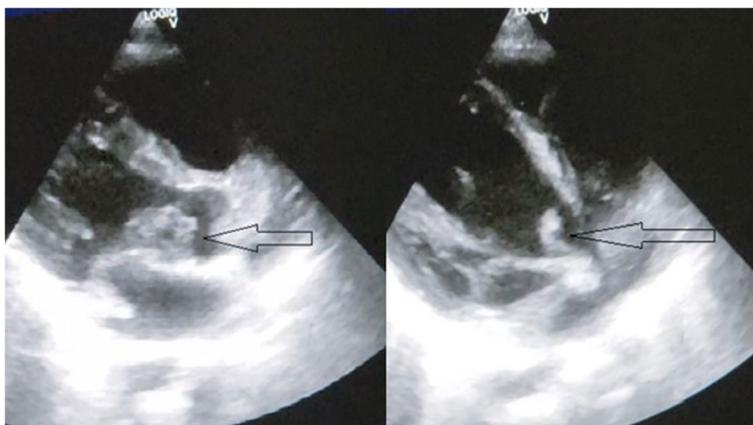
Echocardiography images showing vegetations over the mitral valve
